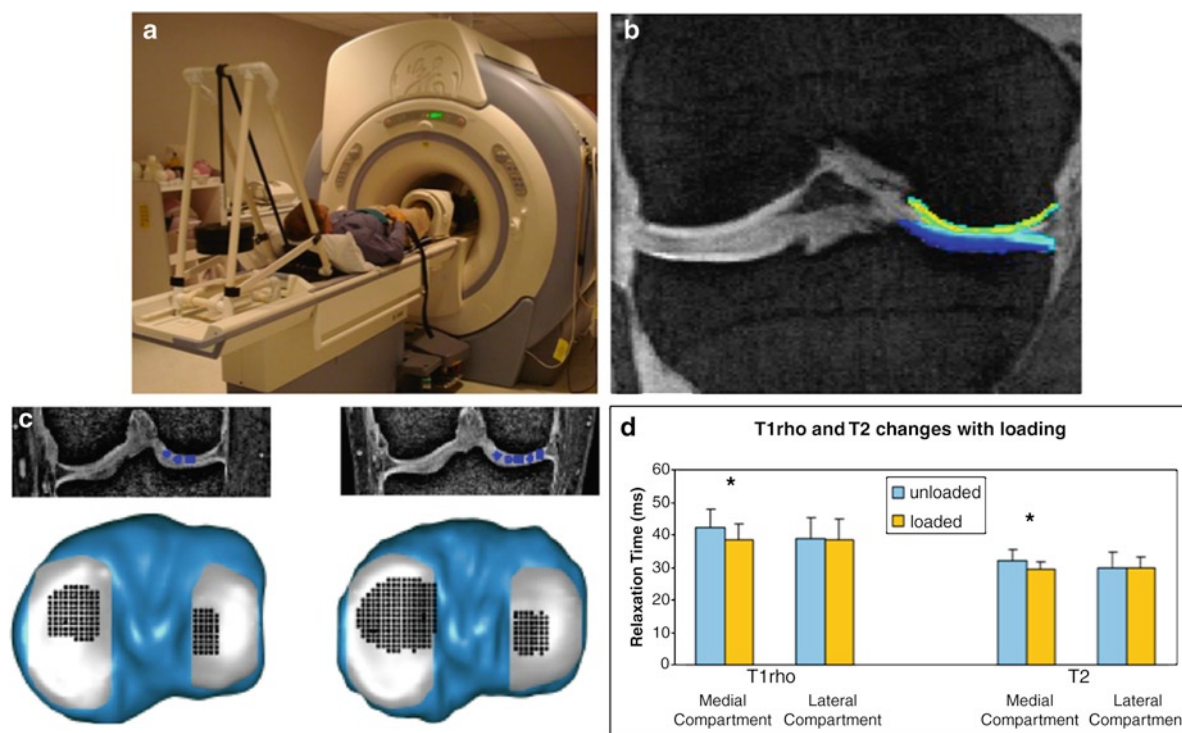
Cartilage in vivo loading: (a) setup during MRI, (b) representative coronal MR image with color map at medial knee compartment, (c) regions with most pronounced changes highlighted, and (d) T1rho
